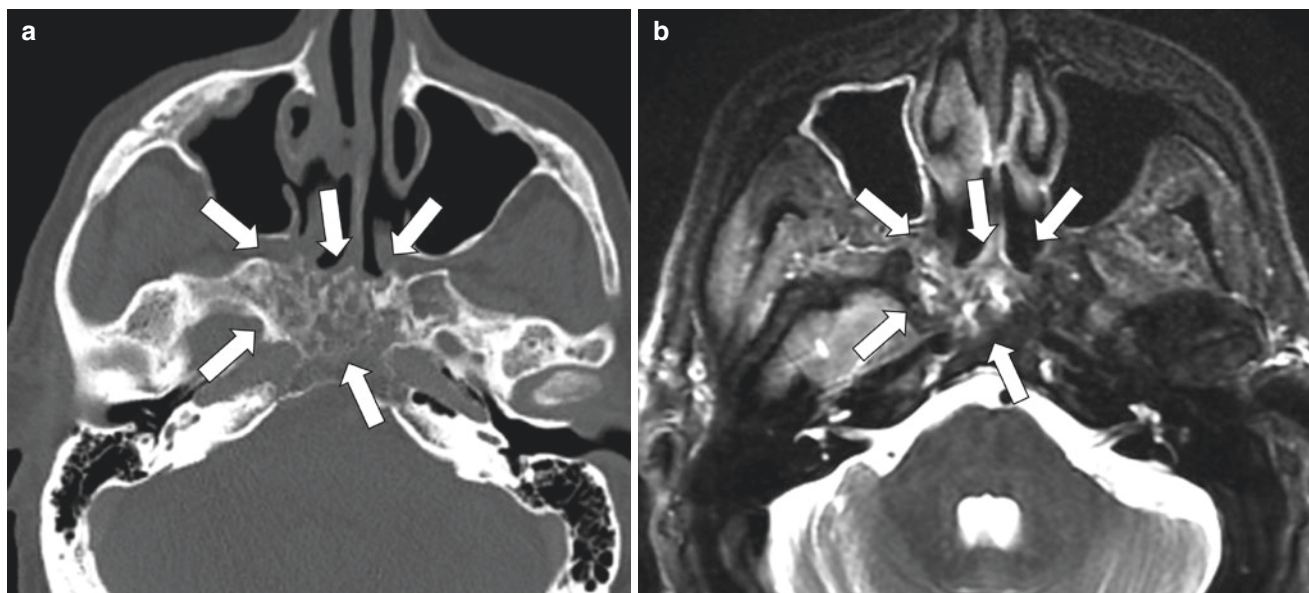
A 72-year-old man after surgery and 21 months after CRT for epipharynx SCC. The skull base bone was heterogeneous on CT, fat-sat T2WI and contrast-enhanced T1WI (a, b, and c, arrows). These findings were potentially indicative of recurrent SCC and skull base invasion. Meanwhile, fused PET images showed that there was
